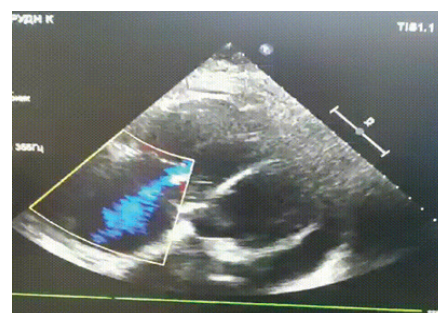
Echocardiography at the time of admission (August 2023). Dilation of all cavities of the heart, overload of the right parts, regurgitation on the tricuspid valve. Fig. 3. echocardiography at the time of admission (August 2023). Dilation of all cavities of the heart, overload of the right parts, regurgitation on the tricuspid valve
